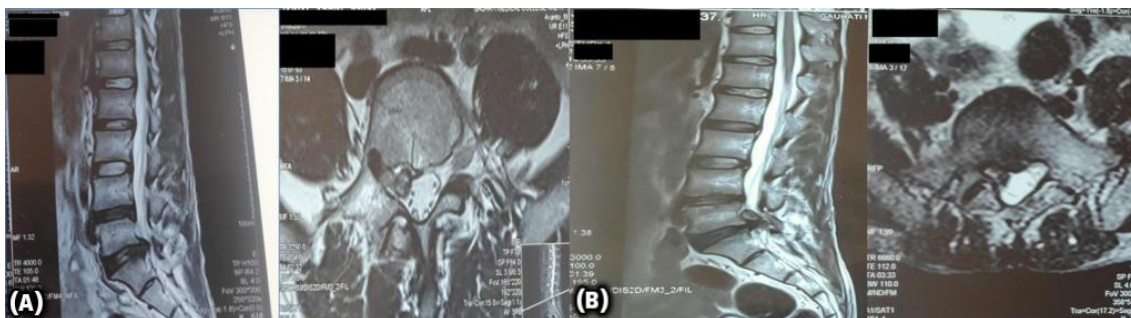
(A) Magnetic Resonance Imaging (MRI) film prior to the first surgery, showing extrusion of the intervertebral disc at the L5-S1 level. (B) Follow-up MRI film at 18 months, showing recurrent extrusion of the intervertebral disc at the same level (L5-S1).
